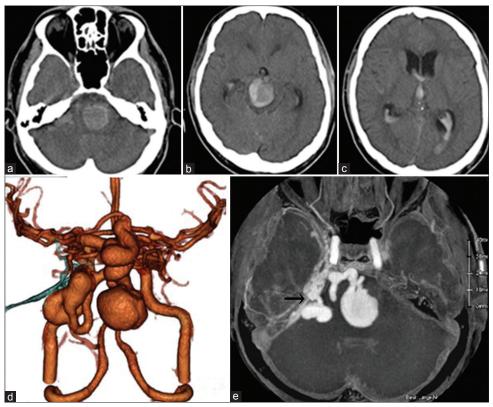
(a-c) CT showed a hematoma at the pons and midbrain with intraventricular hemorrhage and acute hydrocephalus. (d) 3D-CTA showed a large and multiple venous ectasia. (e) The shunting point was at the right cerebellar tent near the petrosal bone (black arrow)
